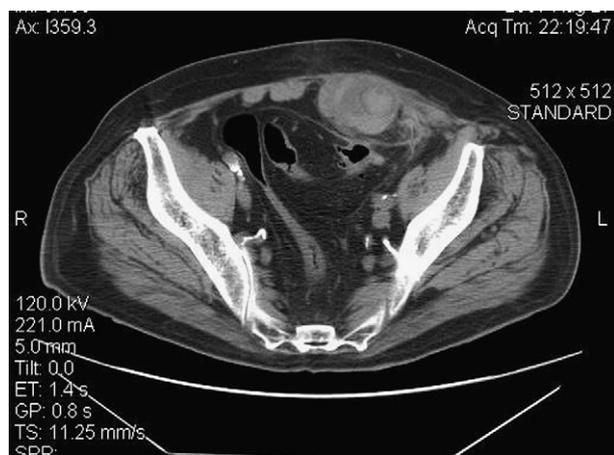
Computed tomography scan of the pelvis demonstrating a left-sided type I RSH measuring $4.2 \times 4.4 \times 11$ cm in a 78-years old man under anticoagulation therapy.
